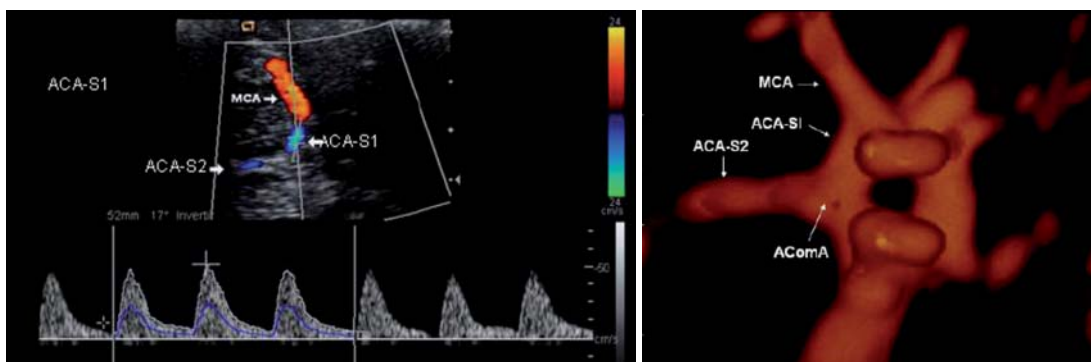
Doppler assessment of the anterior cerebral artery at the level of the circle of Willis (a); power Doppler image of the circle of Willis (b)*
